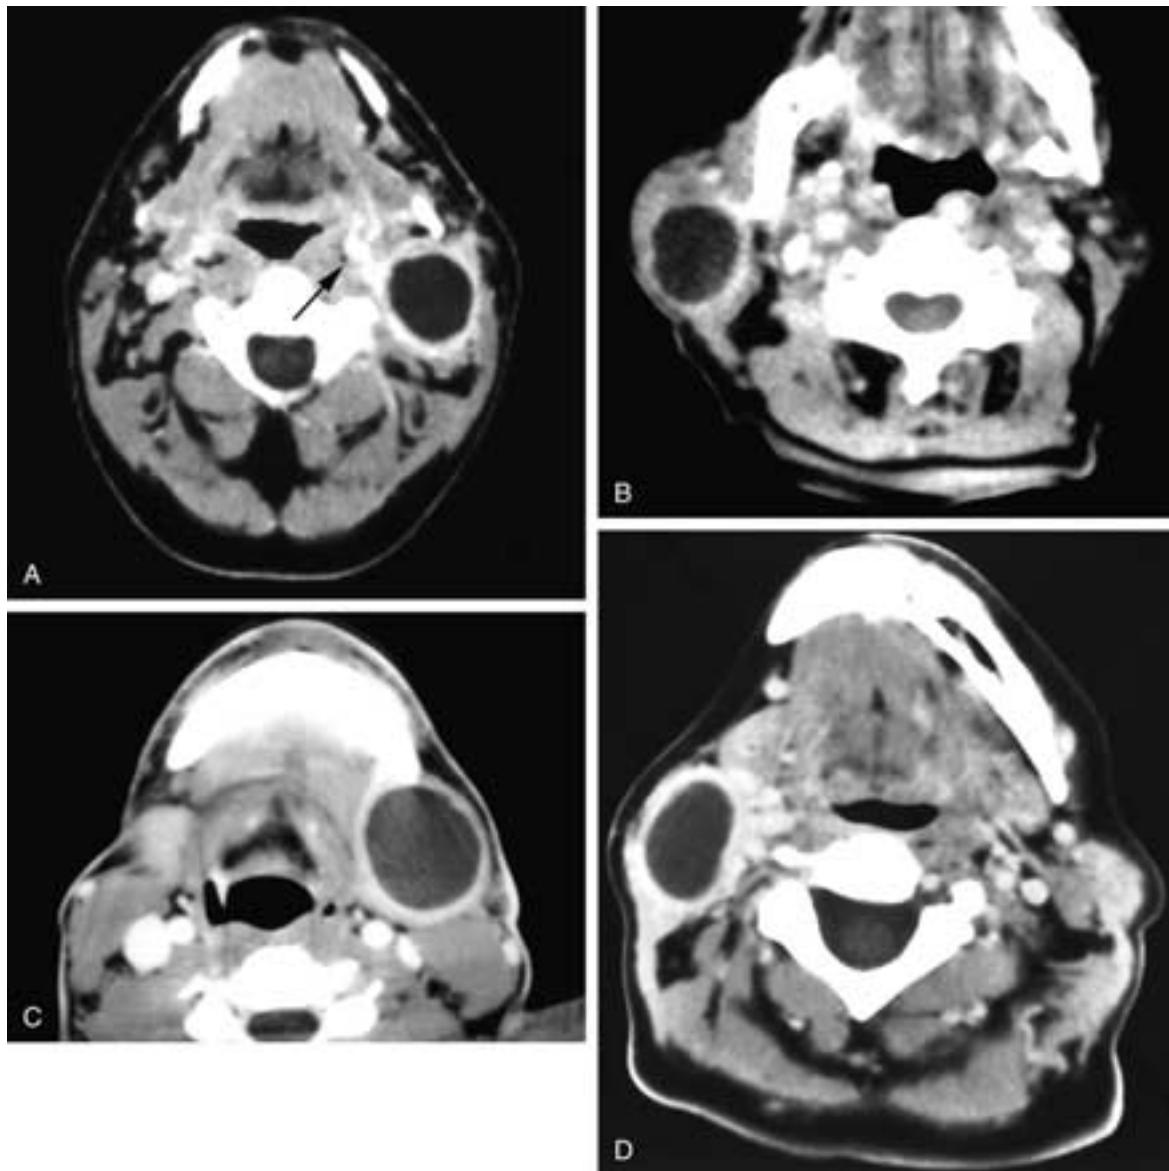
A, Axial contrast-enhanced CT scan shows a left-sided cyst with a thick, enhancing rim. This cyst is behind the submandibular gland, lateral to the carotid sheath structures, and deep to the anterior margin of the sternocleidomastoid muscle. There is an enhancing tract (*arrow*) extending from the cyst toward the left palatine tonsil. This was an infected second branchial cleft cyst with an internal tract. Such a tract typically passes between the internal and external carotid arteries and ends in the palatine tonsil. B, Axial contrast-enhanced CT scan shows a cyst in the right parotid gland with a thick but uniform cyst wall. This was a branchial cyst with no associated tract. Because of its fairly caudal location within the parotid gland, this most likely should be classified as a type II first branchial cyst. C, Axial contrast-enhanced CT scan shows a cyst in the left neck with a uniform, fairly thick, enhancing rim. The cyst is behind the submandibular gland, lateral to the carotid sheath structures, and along the anterior margin of the sternocleidomastoid muscle. This was an infected second branchial cleft cyst. D, Axial contrast-enhanced CT scan shows a cyst in the right neck with a fairly thick, enhancing rim. The cyst is behind the submandibular gland, lateral to the carotid sheath structures, and along the anterior margin of the sternocleidomastoid muscle. This was an infected second branchial cleft cyst.
